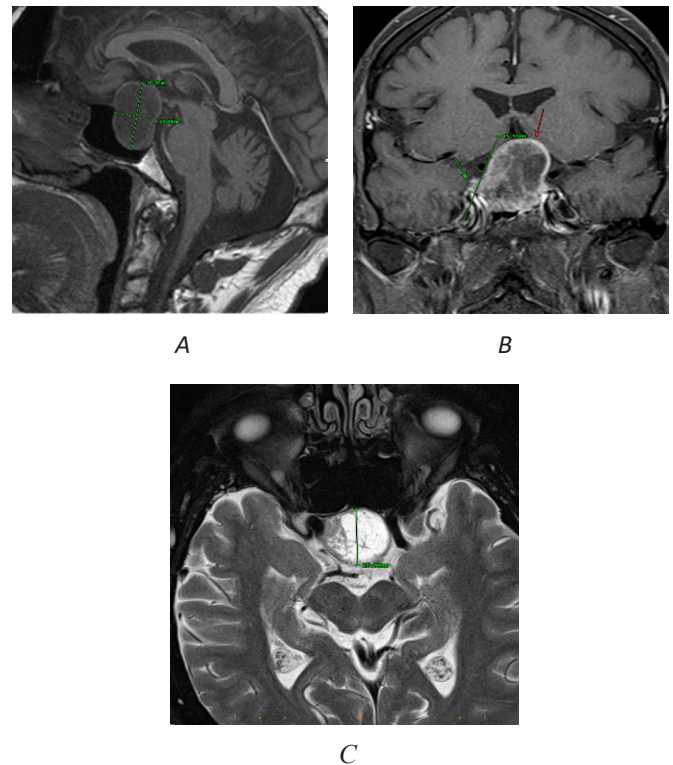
Preoperative MRI findings A) MRI findings of a large sellar and suprasellar solid-cystic macroadenoma; B) Peripheral contrast-enhancement of the solid component on the right. The optic chiasm is cranially displaced and compressed (red arrow). Bilateral anterior cerebral artery (ACA) and anterior communicating artery (ACoA) are also located craniodorsally, but no signs of infiltration exist. On the right, suspicion of infiltration of the cavernous sinus, as we have a solid mass up to the lateral intercarotid line (green arrow); C) The pituitary fossa is enlarged to 25 mm (anteroposterior).
